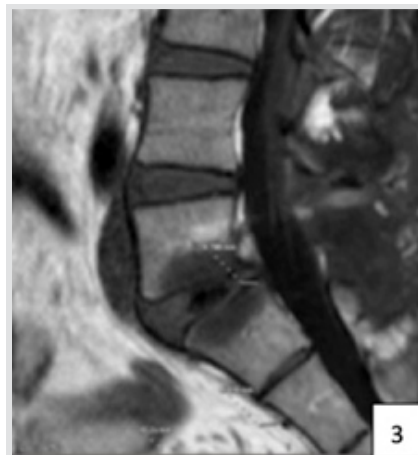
Post-operative magnetic resonance imaging showing non-specific marrow edema and absence of fluid for targeted computed tomography-guided biopsy.
